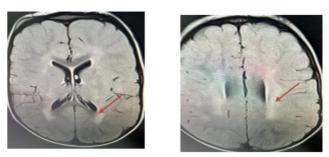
Cerebral MRI, High signal area in the supratentorial periventricular white matter related to the metachromatic leukodystrophy
